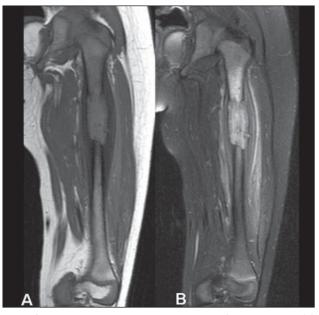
Magnetic resonance imaging — coronal, T1-weighted image (A) and T2-weighted image with fat saturation (B).
